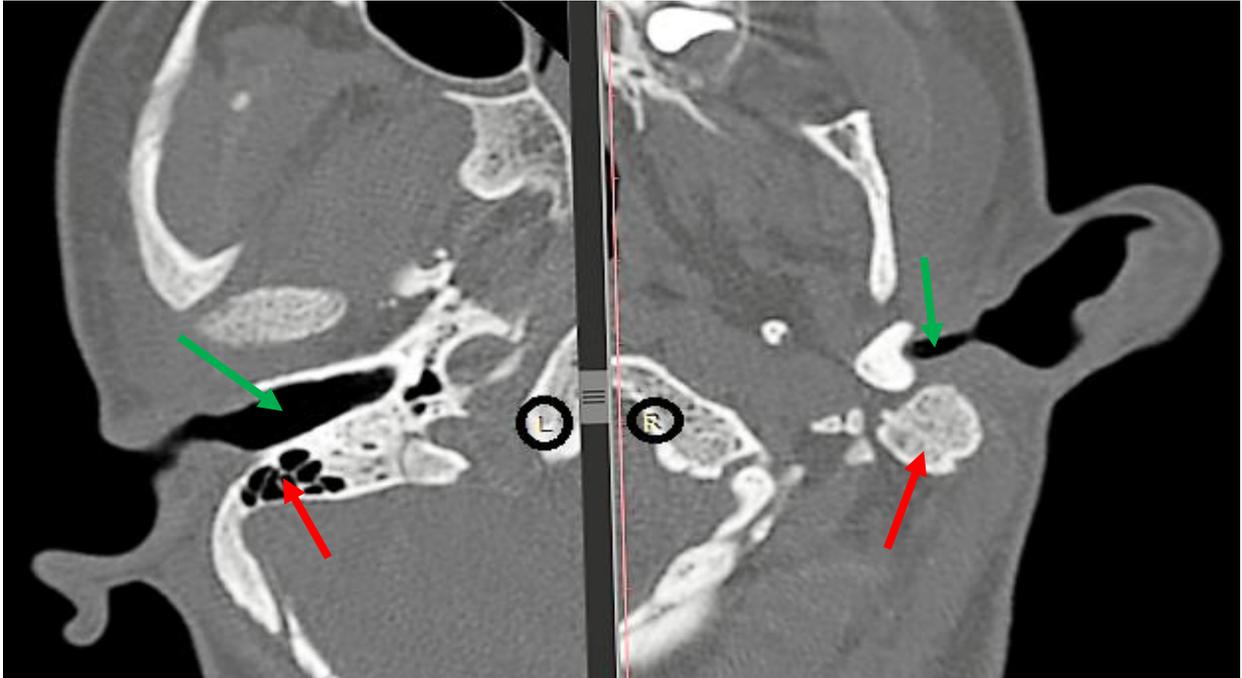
CT axial images showing left small external auditory meatus and external auditory canal as compared to right. (→).
